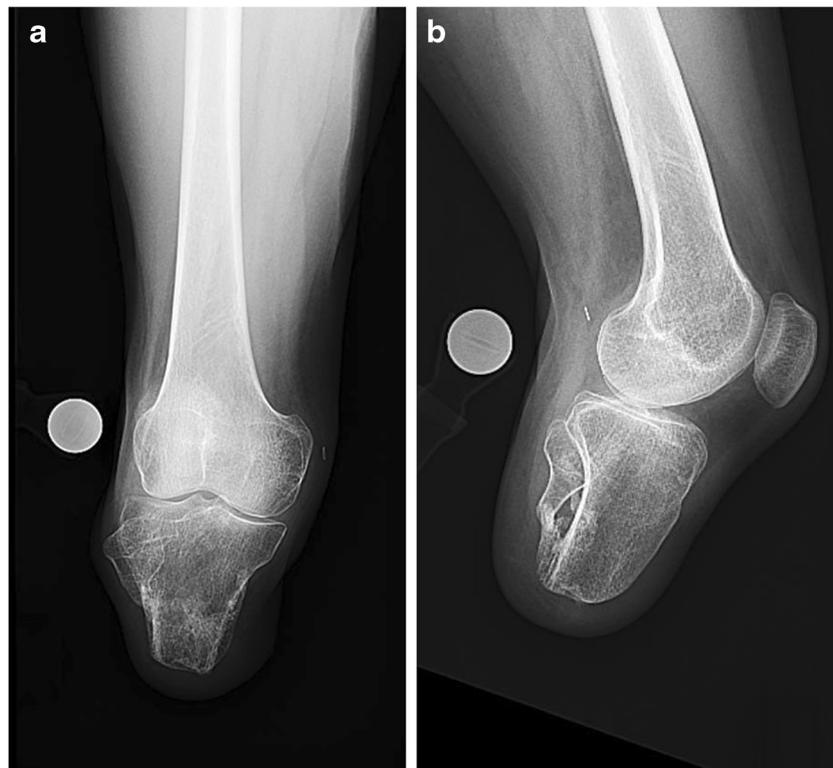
Anteroposterior (AP) and lateral radiographs of the right limb showing a 7-cm residual tibia and fibula.
